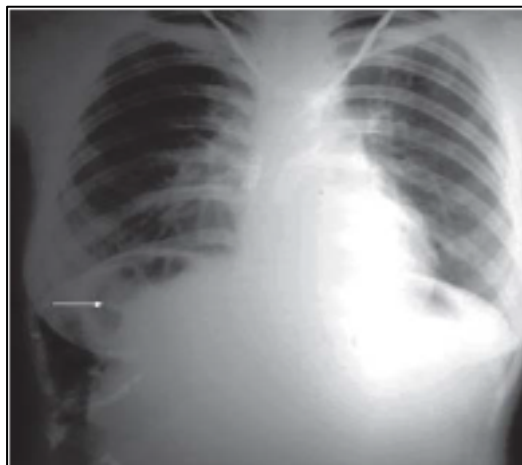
CLASSICAL “GAS UNDER DIAPHRAGM” ON XRAY
